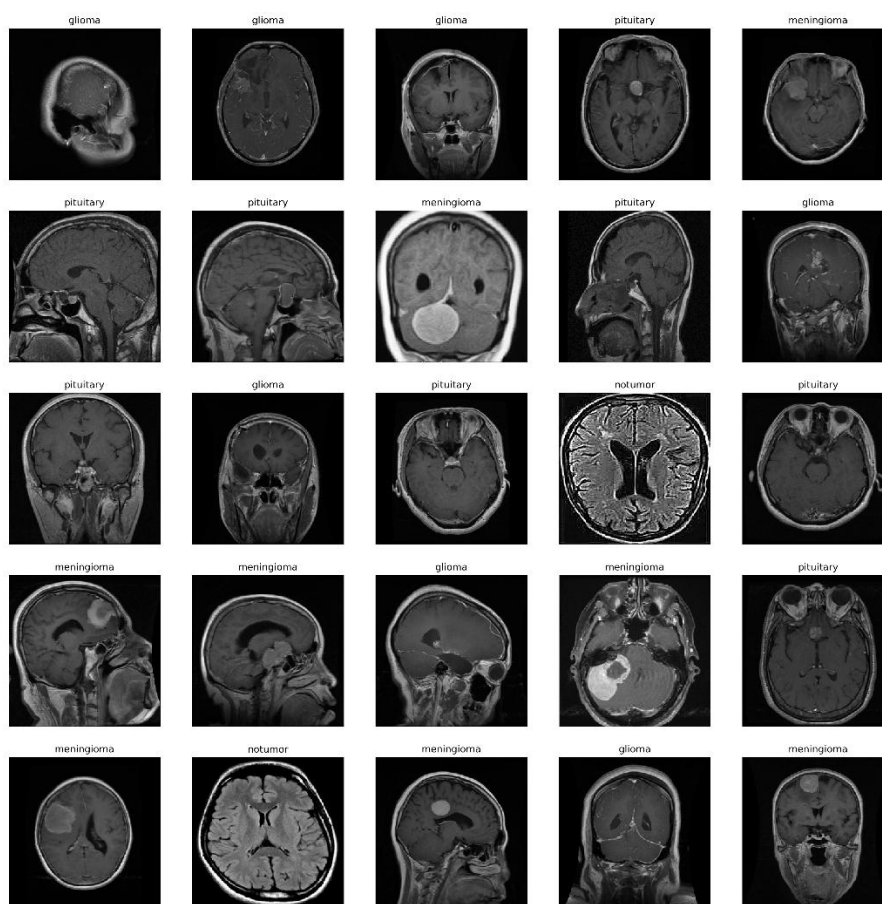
Sample MRI Images used in the study
